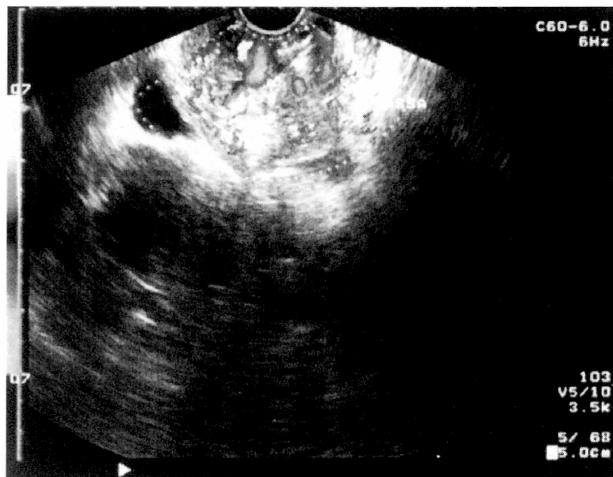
Transvaginal ultrasonography with Doppler showed normal adnexae and uterus. A heterogeneous mass (7.6 x 4.3 x 6.2 cm, volume: 110 cm³) is situated between the bladder, vagina and uterus with intense vascularity and gases inside.
